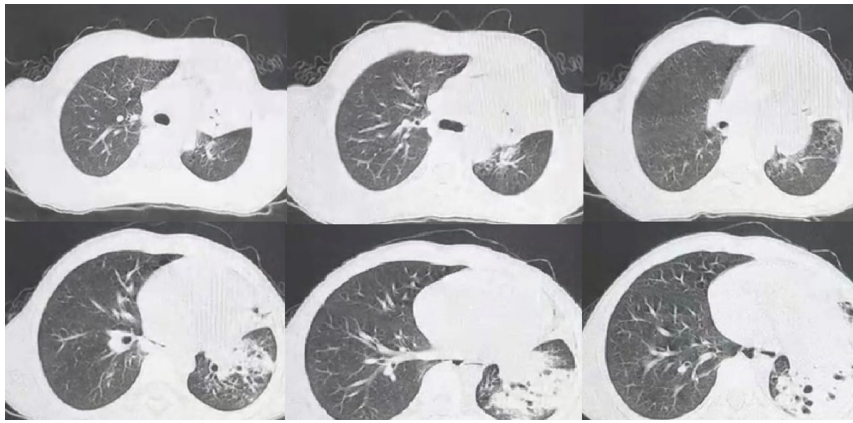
The High Resolution Computed Tomography (HRCT) of the patient before cast removal, indicating atelectasis of the left lower lung
